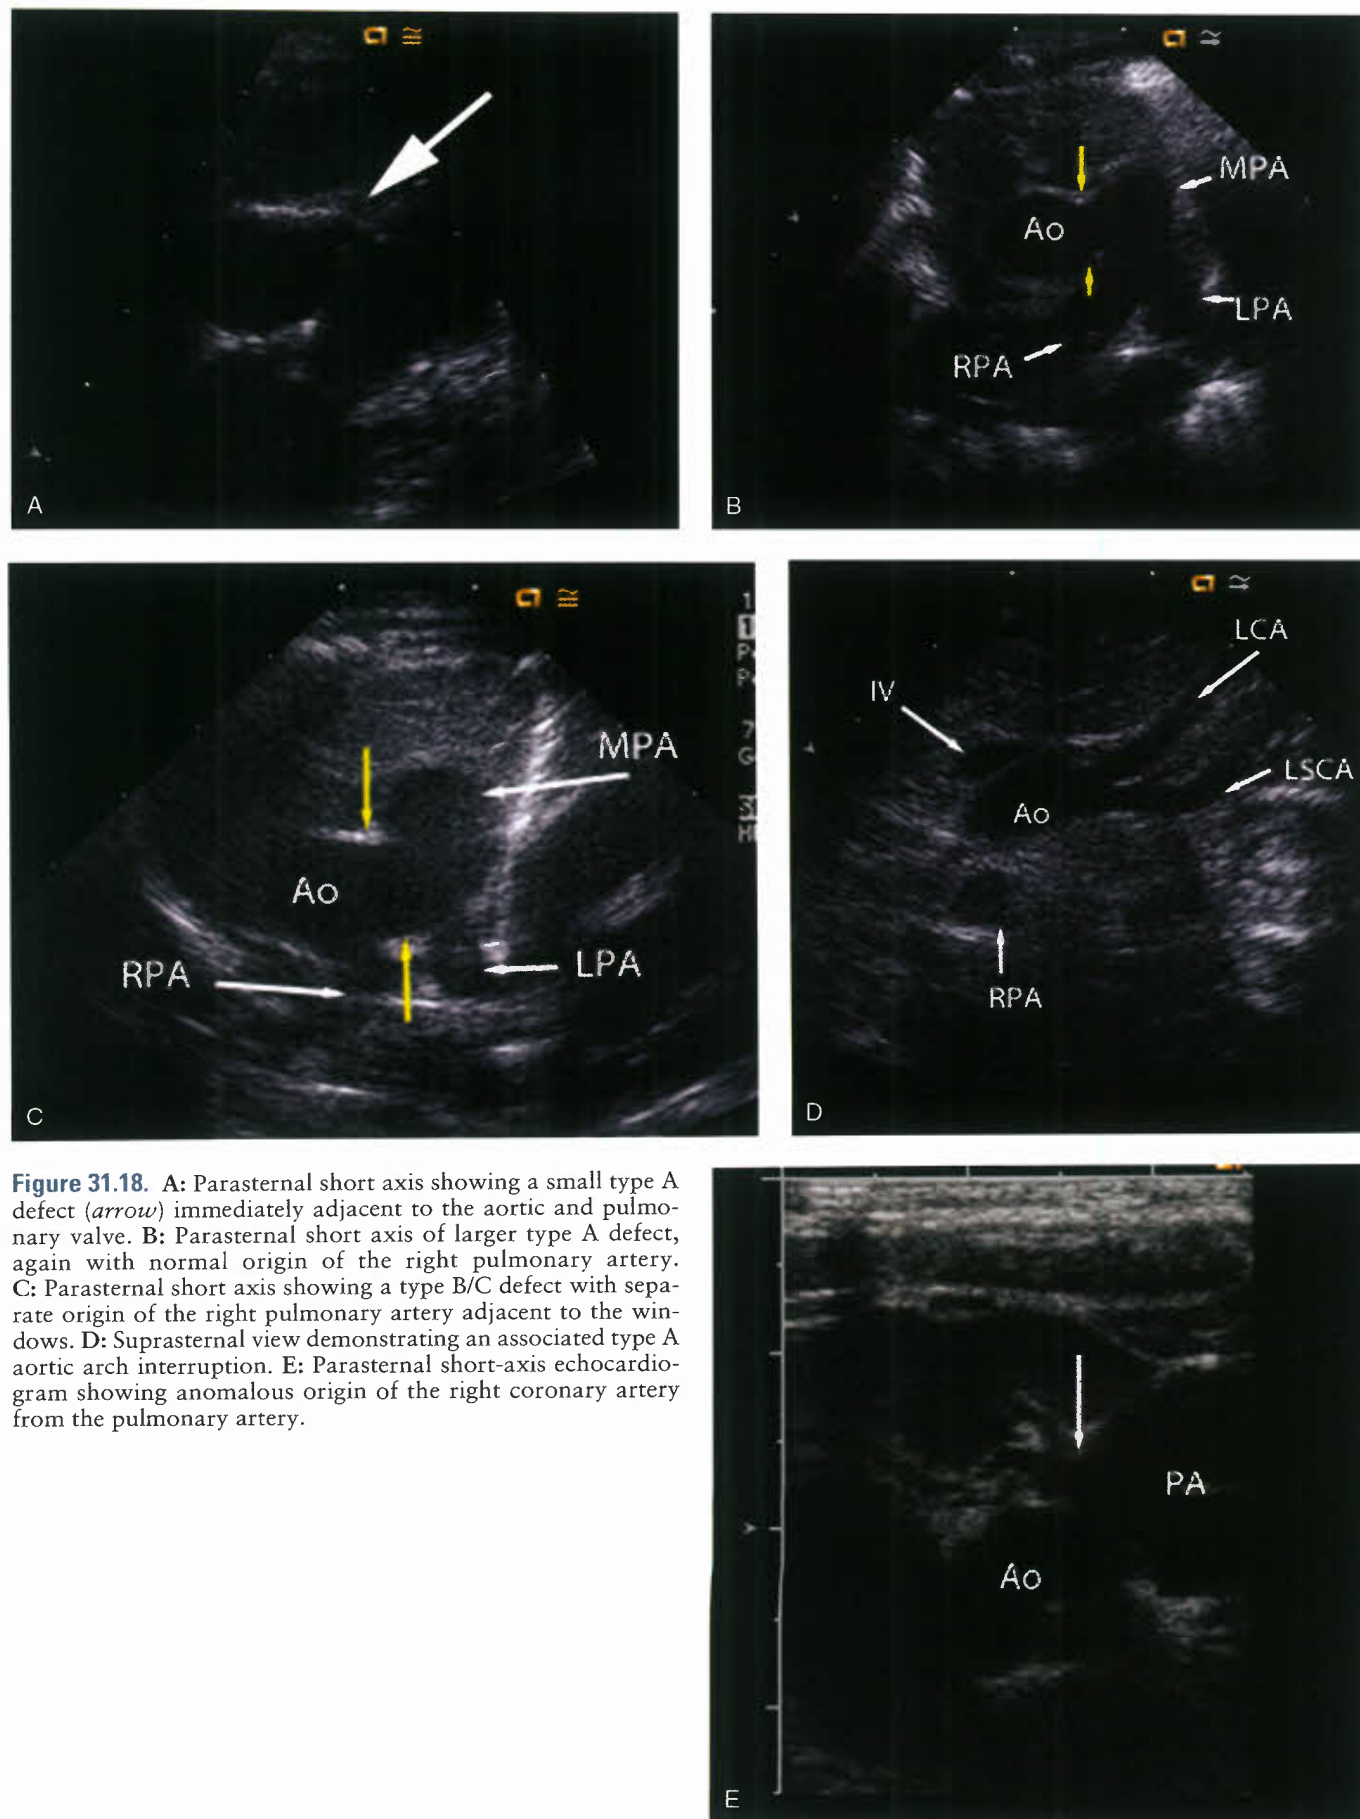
A: Parasternal short axis showing a small type A defect (arrow) immediately adjacent to the aortic and pulmonary valve. B: Parasternal short axis of larger type A defect, again with normal origin of the right pulmonary artery. C: Parasternal short axis showing a type B/C defect with separate origin of the right pulmonary artery adjacent to the windows. D: Suprasternal view demonstrating an associated type A aortic arch interruption. E: Parasternal short-axis echocardiogram showing anomalous origin of the right coronary artery from the pulmonary artery.
